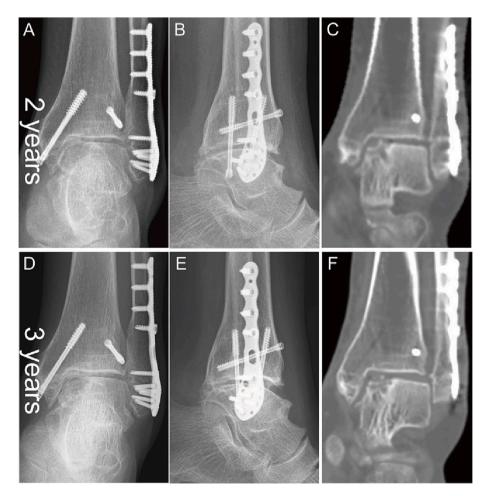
Postoperative imaging showed no evidence of progression of ankle osteoarthritis (A-C, 2-year postoperative; D-F, 3-year postoperative). CT scans showed the graft was merged with the talus, and circumferential ossification was formed at the graft-bone interface (C, F).
